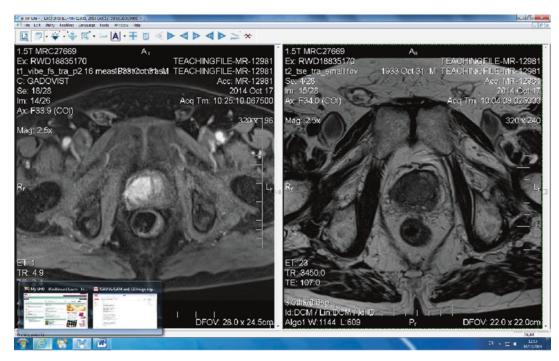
Vendor provided DICOM viewer to display different image slices side by side. Using this facility it is easy to identify matching T2-weighted and the corresponding DCE MRI image of the same section
